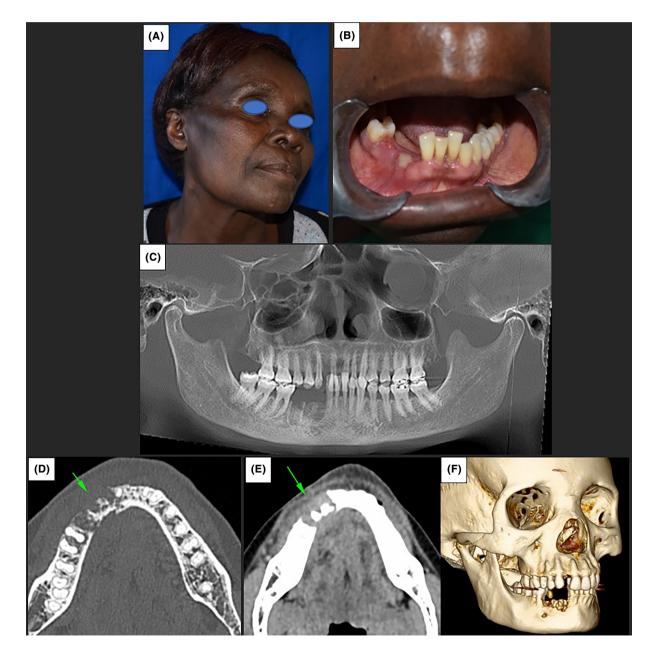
Clinical and radiological presentation. (A) Swelling on the right body of the mandible extending to the angle. (B) Exposed bone area on the 44/45 area with suppuration. (C) Digital OPG showing a mixed radiolucent-radiopaque lesion on the 44/45 area. (D) Axial view, bone window CT scan showing lingual and buccal decortication with sequestration. (E) Axial view, soft tissue window CT scan showing an area of bone destruction on the 44/45 area.
